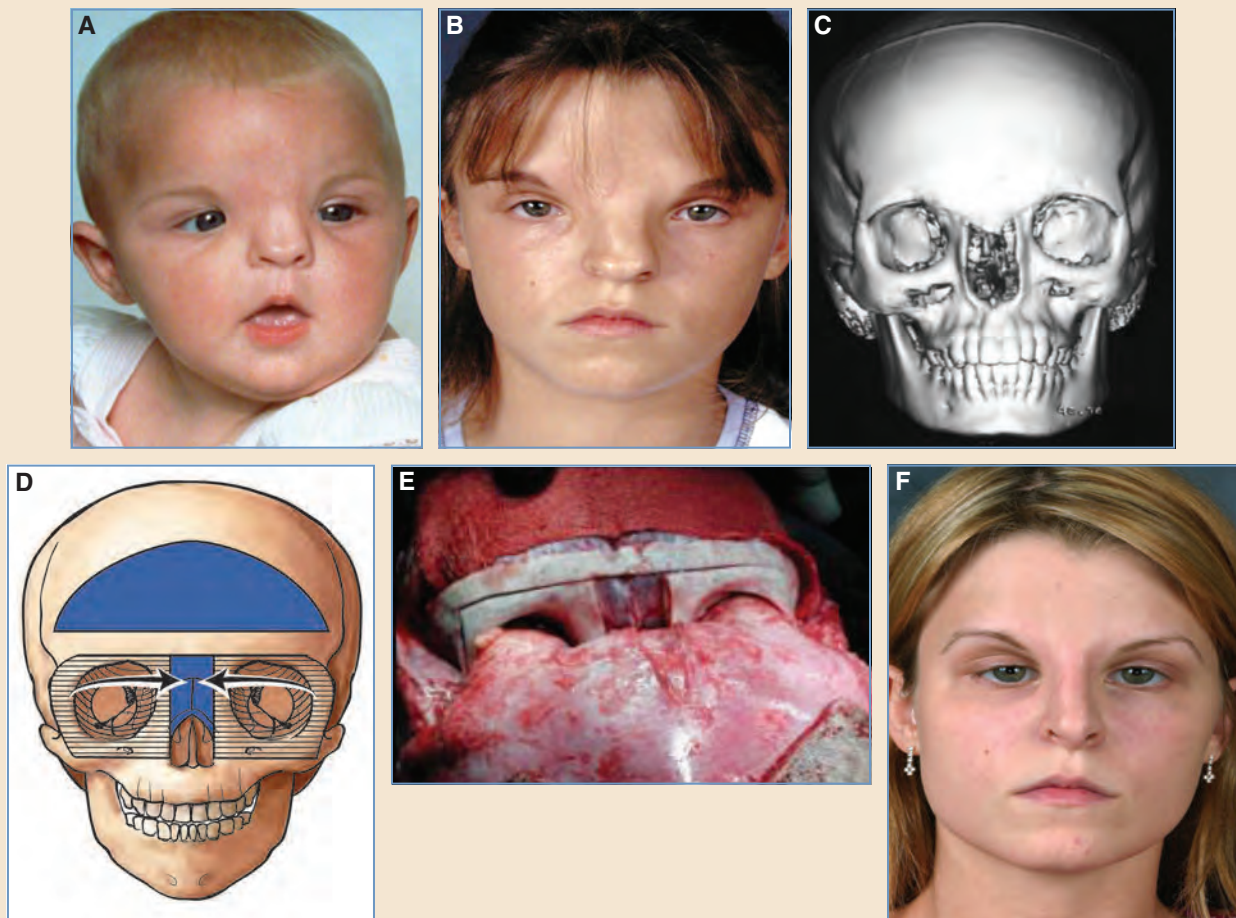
Typical hypertelorism (see Chapter 35 for a case of atypical hypertelorism). A, Patient at infancy. B, Patient at 14 years of age with asymmetrical hypertelorism (atypical craniofacial cleft, bilateral Tessier 12-13). C, Preoperative three-dimensional CT scan. D and E, She underwent "box" orbital osteotomies at 15 years of age, followed by a nasal dorsal rib graft at age 16. F, Postoperative image at 17 years of age. The excess forehead skin was managed with an internal cinch suture. Further surgery is planned to aesthetically define the medial supraorbital rim and brow. (Courtesy of Pravin Patel, MD.)
